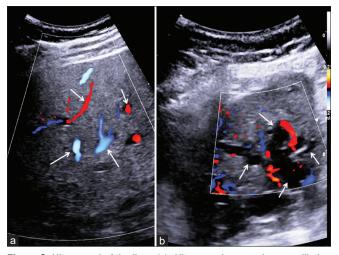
Ultrasound of the liver. (a): Ultrasound scans show no dilation of the right bile ducts; Hepatic veins (arrows) and (b) left bile ducts dilatation (arrows)
